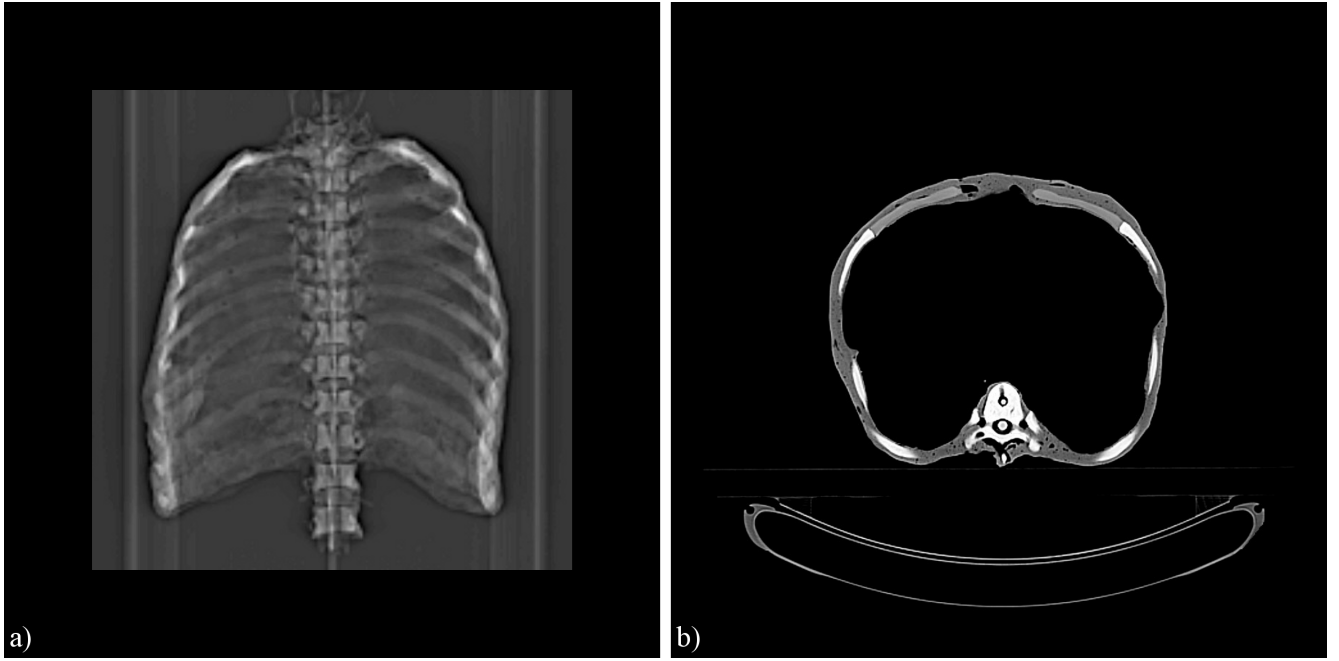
CT scan of the thorax. (a) Topogram (b) Representative axial slice
